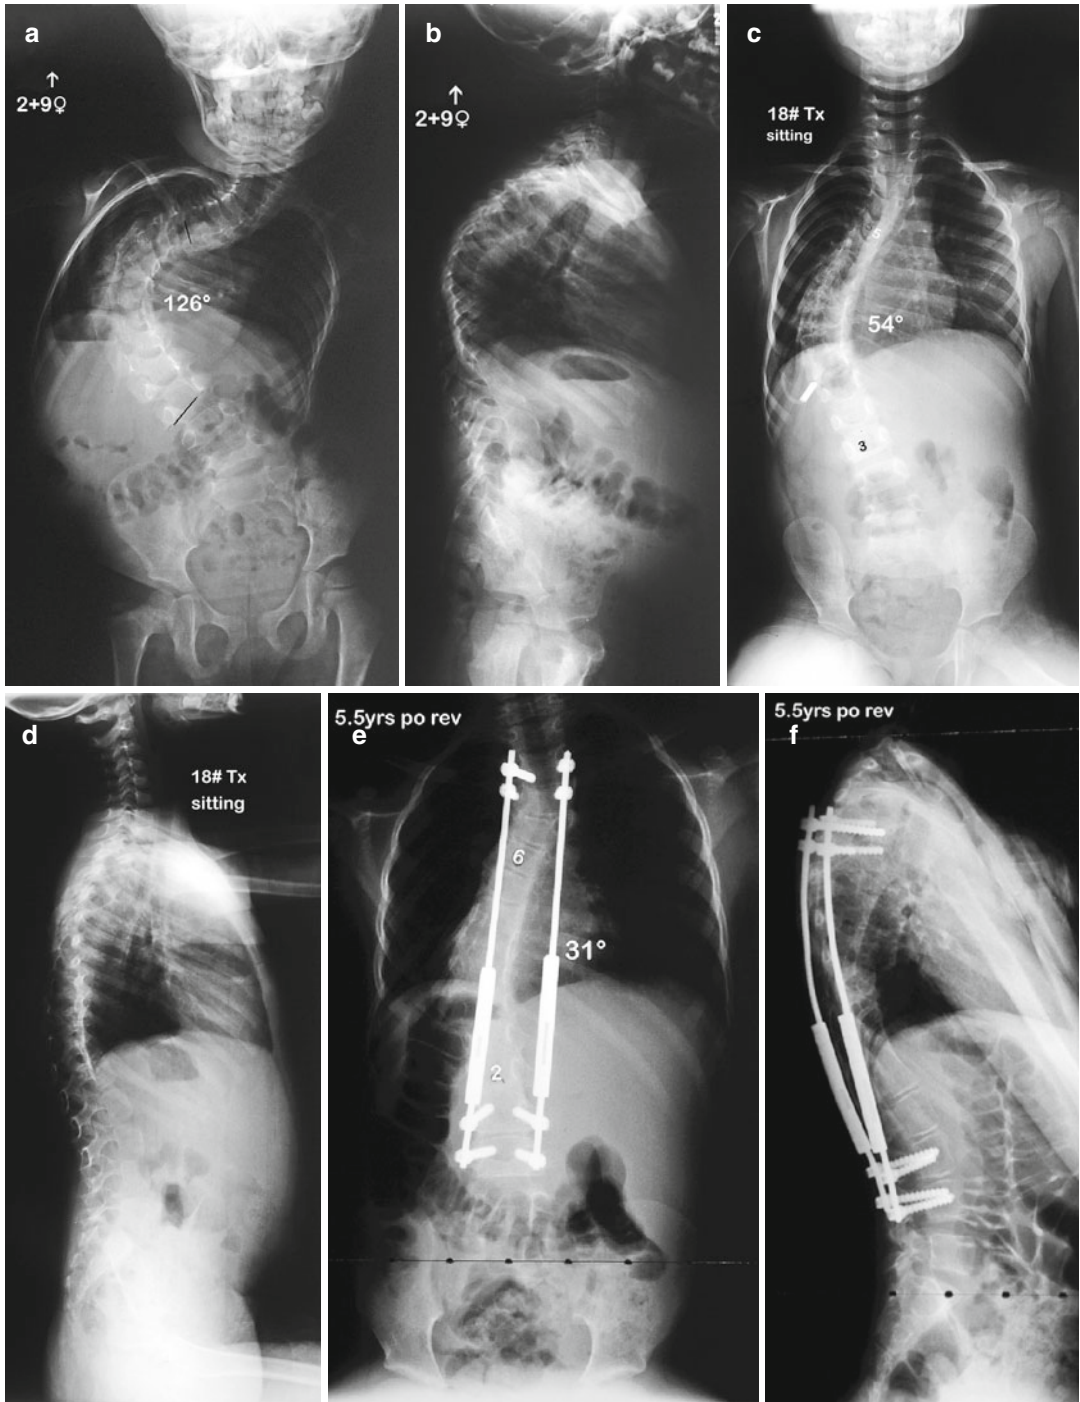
Patient is a 2+9-year-old female with infantile idiopathic scoliosis. (a, b) She presented with a 126° scoliosis and thoracic kyphosis deformity. She had a normal total spine MRI and a negative genetics evaluation. She was placed in preoperative halo-gravity
